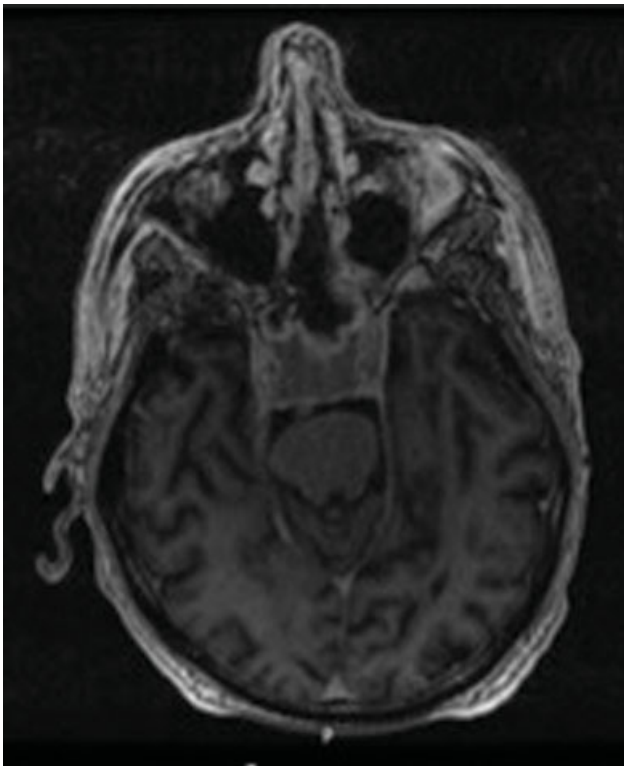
MRI of the head with and without IV contrast demonstrating diffuse metastatic infiltration and destruction of the clivus.
